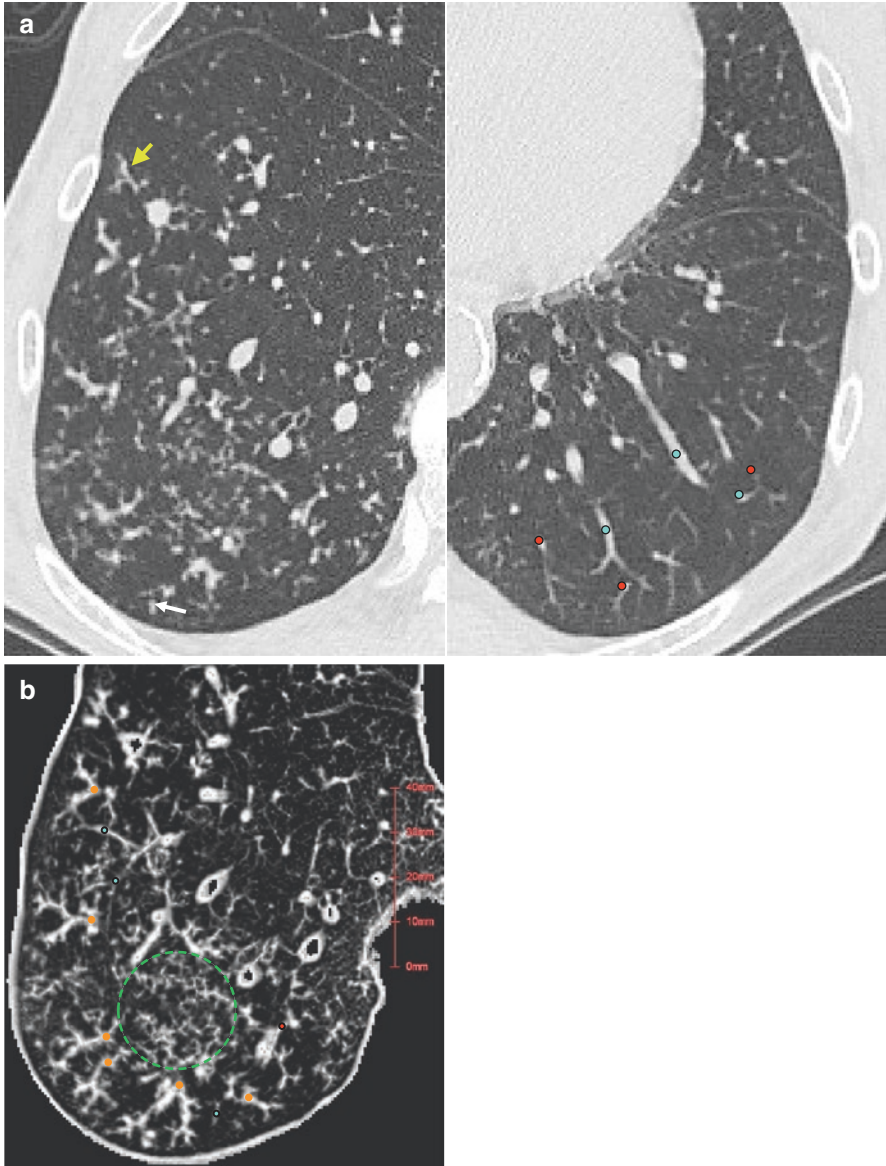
High-resolution computed tomography (HRCT) image of pulmonary TB. 3D-computed tomography (right lung) in the same case as the conventional HRCT image (left and right lungs). In the left lung in Fig. 6.8a, pulmonary arteries (red circles) that can be regarded as almost normal can be observed. In comparison, in the lower right lung, thicker, bifurcated shadows with high absorbance can be observed up to the centrilobular nodule (thick arrow). There is also a centrilobular and branching nodule (thin arrow). In Fig. 6.8b, by continuously superimposing the HRCT images, abnormal bifurcated shadows extending inside and outside the lobule up to the centrilobular nodule are rendered (orange circles). There is no abnormality in the pulmonary veins (blue circles). In the image, there is an abnormal bifurcation shadow and the pulmonary artery is pre-empted to be split (red circle). A fine abnormal bifurcated shadow can be observed in the center, slightly to the caudal side of the figure (green dotted line frame: tree-in-bud pattern). Figure 6.8b is taken from Reference 6
